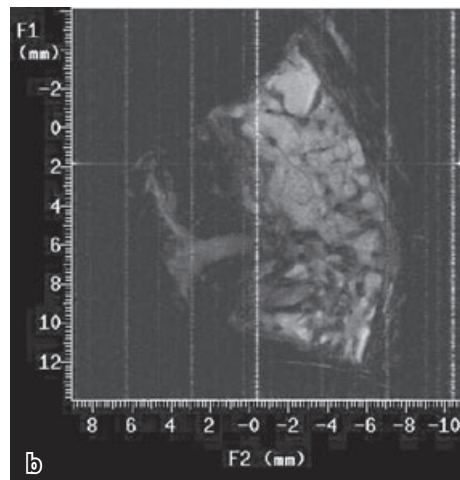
(a) A macroanatomical view of a human anterior mandible showing a clear neurovascular bundle entering the superior genial spinal foramen. (b) A matching horizontal slice acquired through high-resolution MRI confirms the entry of a neurovascular bundle into the superior genial spinal foramen. (Courtesy of Professor I. Lambrichts, University of Hasselt.)
